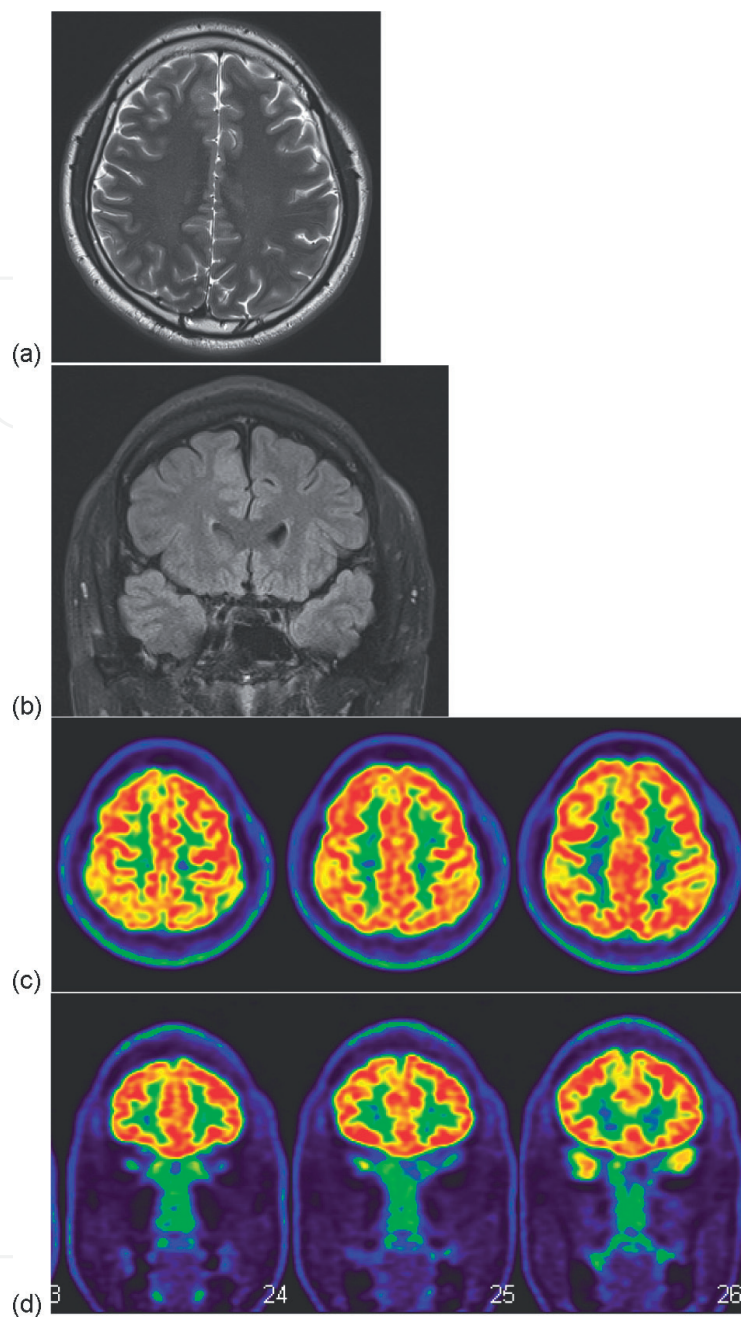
A patient with frontal lobe epilepsy had negative 3T MRI finding (a) and (b); and subsequently, MRI/PET scan showed hypometabolism over left mesial frontal region (c) and (d).
